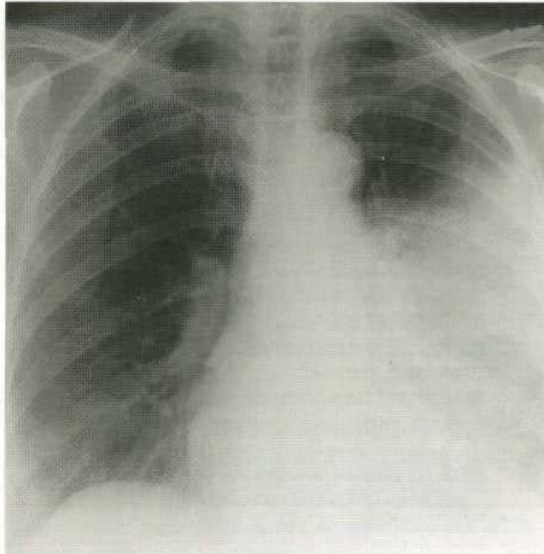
Chest X-ray showing lobar pneumonia.
